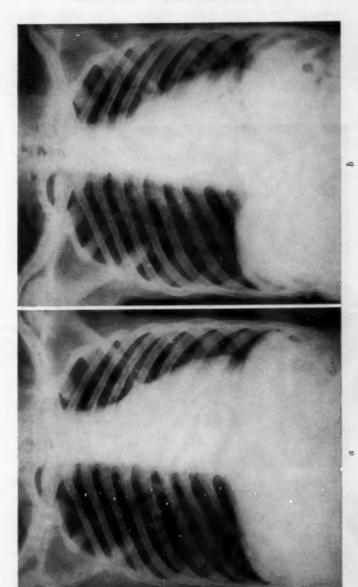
Chest x-ray examination. Deviation of the heart to the left, narrowing of the left intercostal spaces and slight elevation of the left diaphragm indicate atelectasis of the left lung. b. Expiration film reveals the shift of the heart to normal position, but the narrowed left intercostal spaces and slightly elevated left diaphragm remain unchanged.
